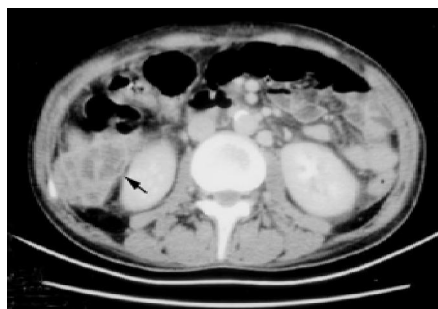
Computed tomography scanning with contrast showed a hypoechoic lesion with irregular and enhanced margin located over segment 6 of liver (arrow), which had ruptured but localized in subhepatic region.
